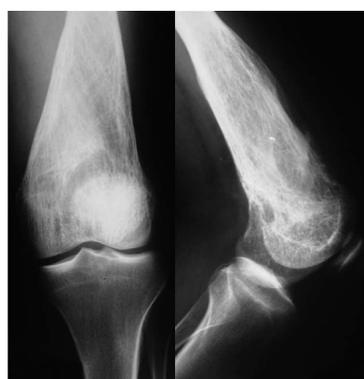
Radiograph at 1 mo follow up. More obvious lysis of the distal femur comparatively to the initial image. Thick and coarse trabeculation is obviously apparent. Cortical breach is clearly found especially to the anterior cortex.
